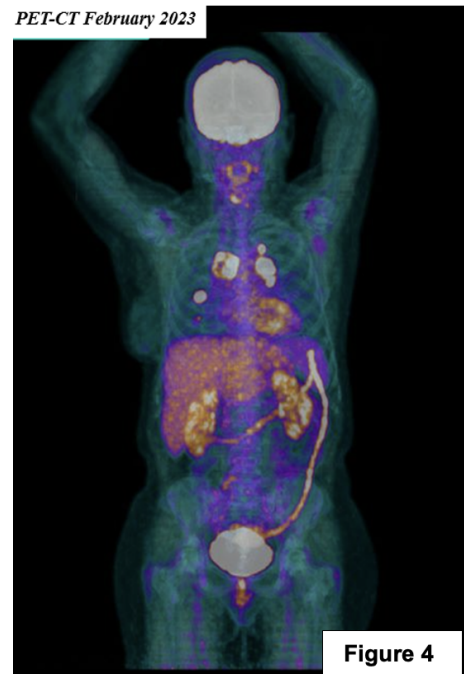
PET-CT showing nodal and pulmonary secondary dissemination of the disease.
